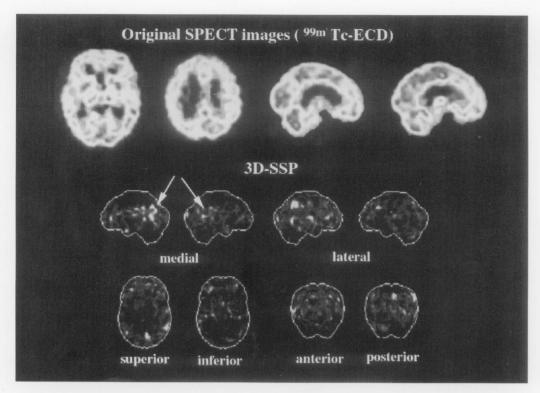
Detection of significant flow decrease in the posterior cingulate gyrus and precuneus (arrows) in a patient with early Alzheimer's disease compared with normal database using three-dimensional stereotactic surface projection (3D-SSP) method. Visual interpretation of original SPECT images can not point out any flow decrease.
